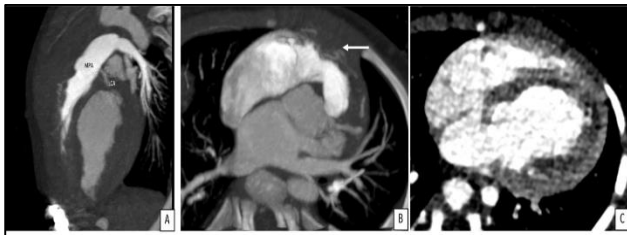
(A-C): Oblique sagittal MIP CT angiogram image showing LCA arising from posterior aspect of main pulmonary artery. Axial MIP CT angiogram image showing multiple tortuous collateral arteries (←) in anterior aspect coursing from right coronary artery to branches of LCA. Axial CT image-shows subendocardial ischemia along left ventricular wall in form of hypo-enhancement.
